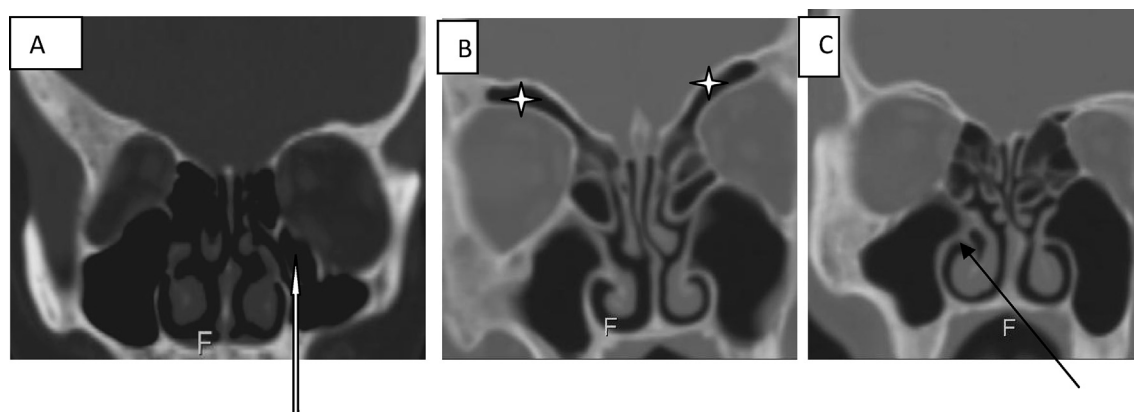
Coronal CT images; (A) Haller's cell (white arrow), (B) supra-orbital cell (↔) and (C) pneumatization of right inferior turbinate (black arrow).
